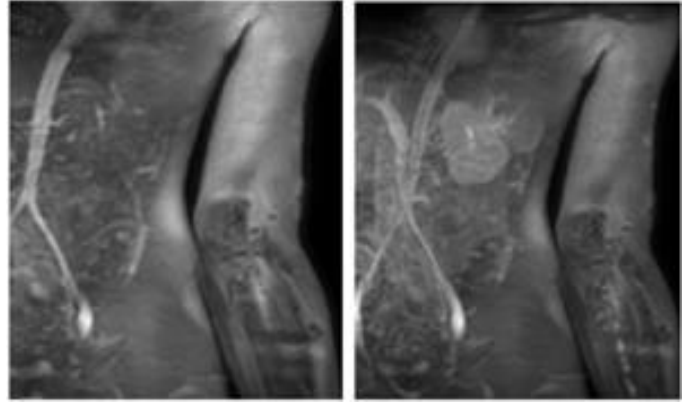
showing Dynamic contrast MRI: - No contrast filling in arterial phase (left). And Minimal contrast filling in venous phase (right)
